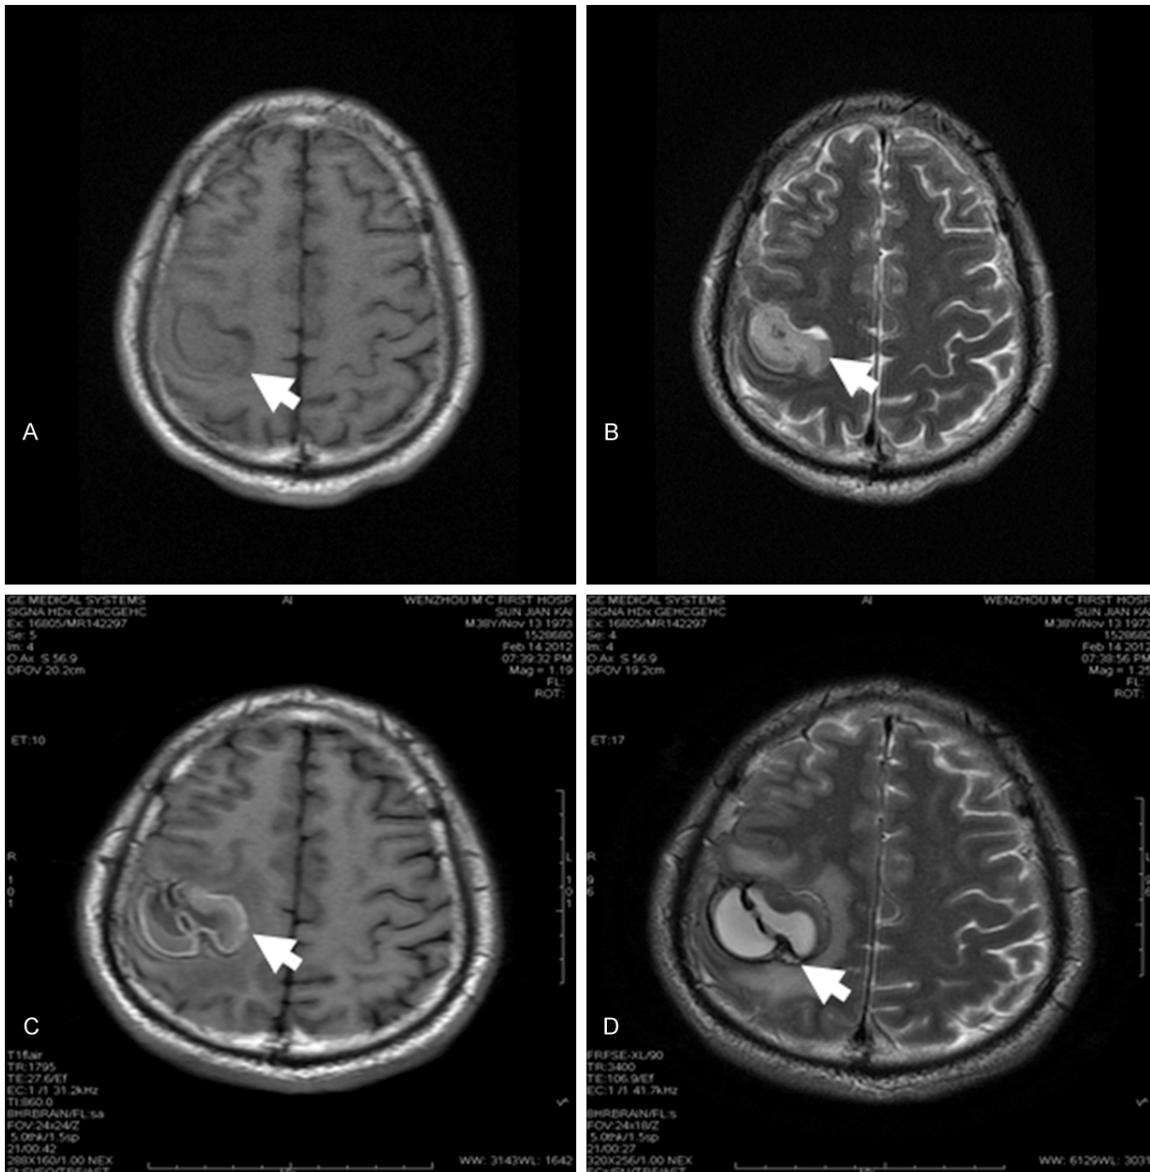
The edema analyzed by MRI imaging. Representative head MRI images were shown. A. T1WI signal was surrounded by a low signal intensity ring (arrow) at the onset of the disease. B. High signal intensity with middle patch of low signal intensity and surrounding slight edema signal (arrow) was seen in T2WI at the onset of the disease. C. Low signal intensity with peripheral ring-shaped high signal intensity (arrow) was seen in T1WI. D. High signal intensity with peripheral visible annular low signal intensity (arrow) was seen in T2WI at 1 month after the onset of the disease. The massive edema zone showed “ring-like shape” around the hematoma and “tunnel-like shape” in the hematoma.
